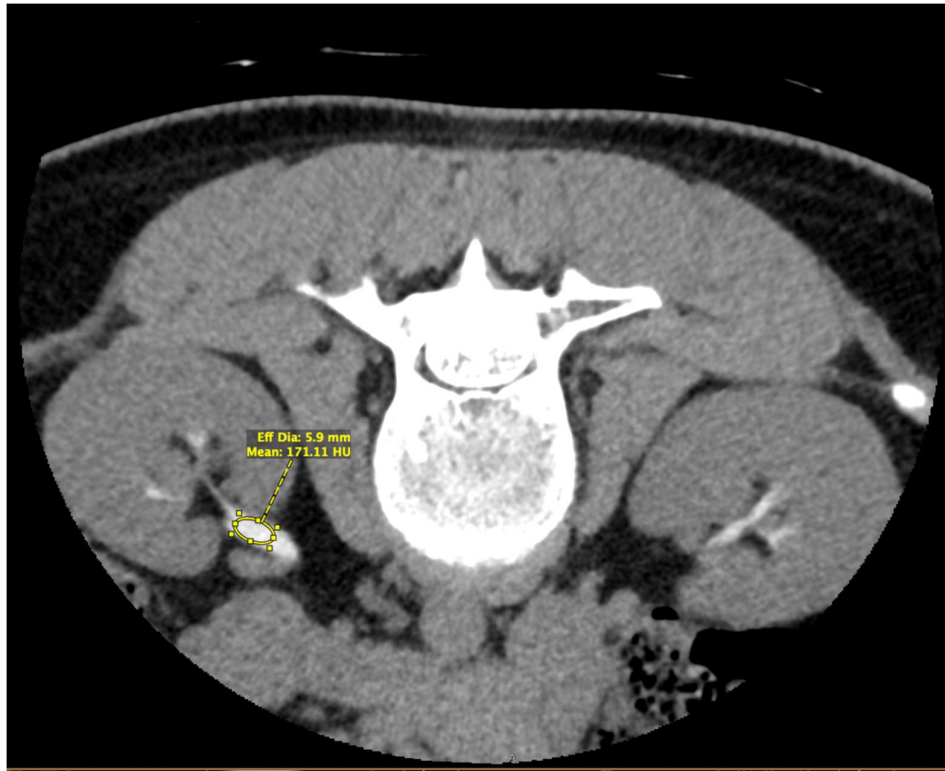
Axial CT image prone CTM for a SIH+ subject with example standardized ROI.
